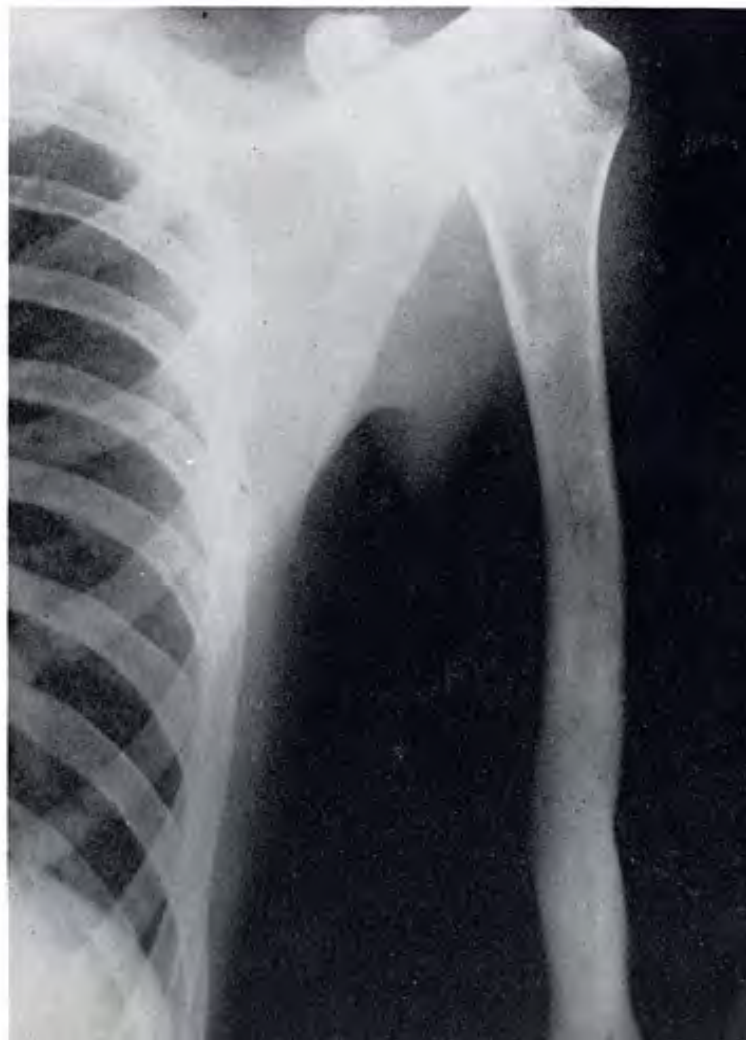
Recent roentgenogram of the left arm (April, 1958).
